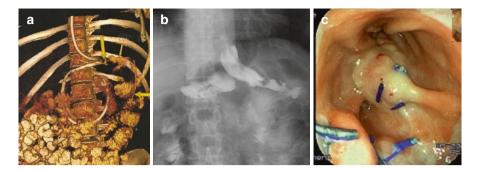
(a) Twisted gastric pouch is identified on CT scan, (b) on contrast X-ray, and (c) on upper gastrointestinal endoscopy (UGE)
